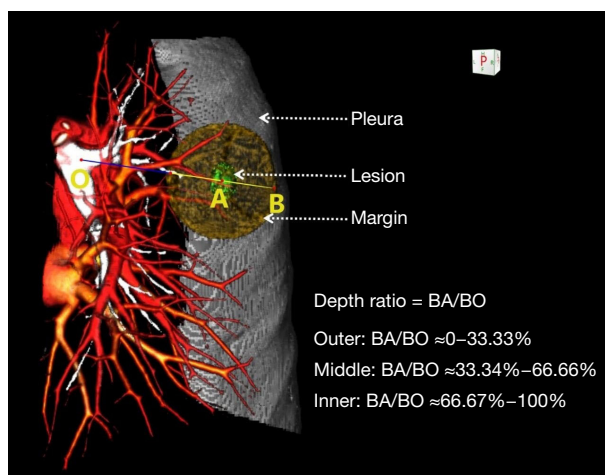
Measurement of the depth ratio in a 3D-CTBA image. The center of the bronchial opening of the pulmonary lobe to which the lung nodule belongs is marked as point O, and the center of the pulmonary nodule is labeled as point A. Extend the line connecting points O and A towards the visceral pleura. The extension that intersects the rib-facing visceral pleura or the well-developed interlobar pleural membrane is marked as point B. The depth of the pulmonary nodule from the hilum is approximately represented by the ratio BA/BO. Nodules with a depth ratio of 0–33.3%, 33.4–66.6%, and 66.7–100% are defined as outer region, middle region, and inner region nodules, respectively. CTBA, computed tomography bronchography and angiography.
